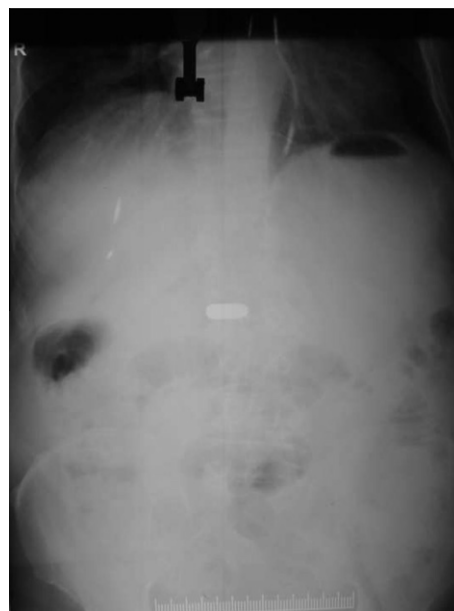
Radiograph (AP view) showing bullet at the level of L2–L3.
